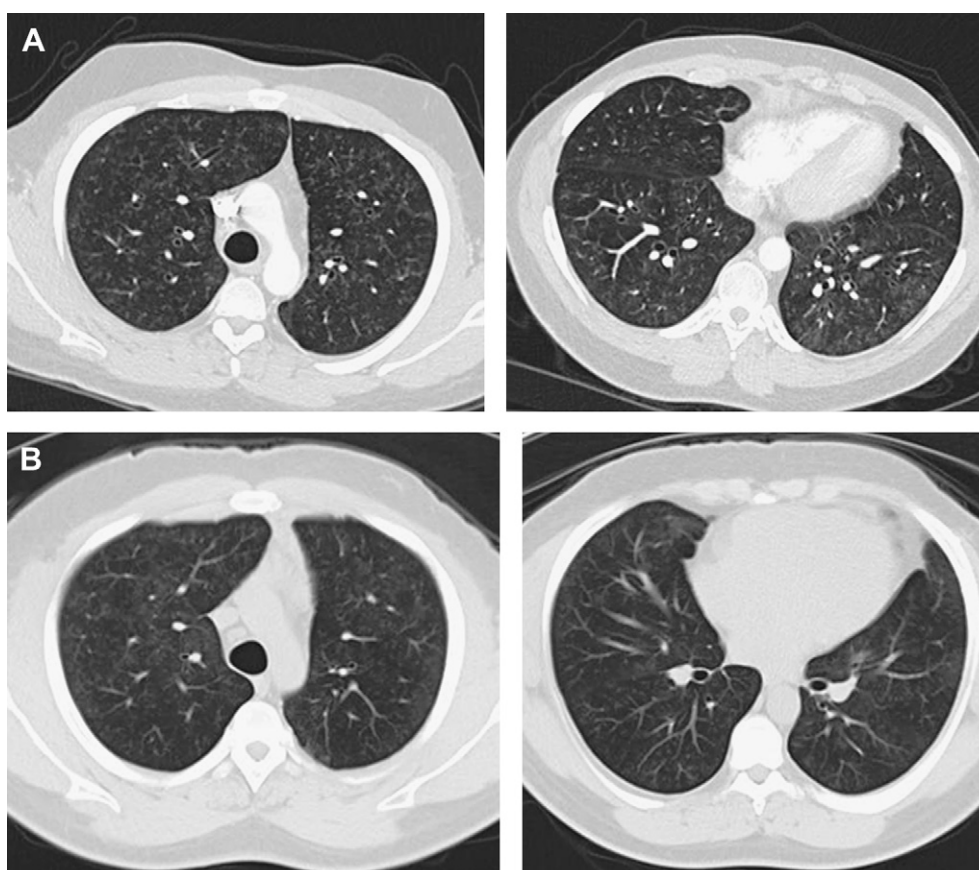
A. Computed tomography of chest at baseline. B. After 3 months of therapy.
